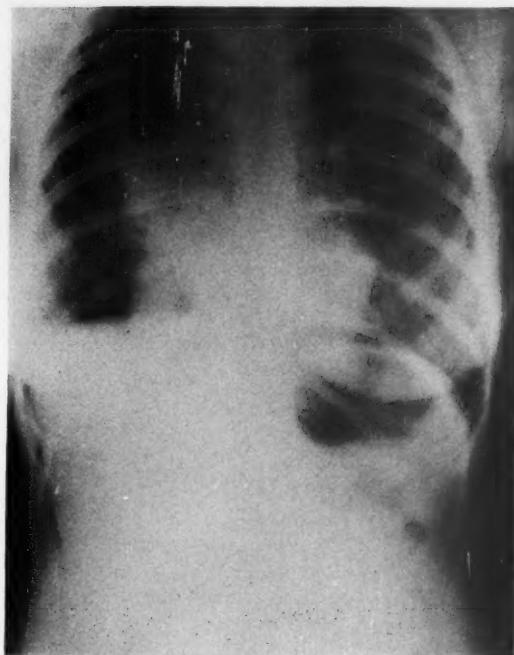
Roentgenogram of chest in posteroanterior projection in Case 3 showing subcutaneous emphysema and pneumothorax.
